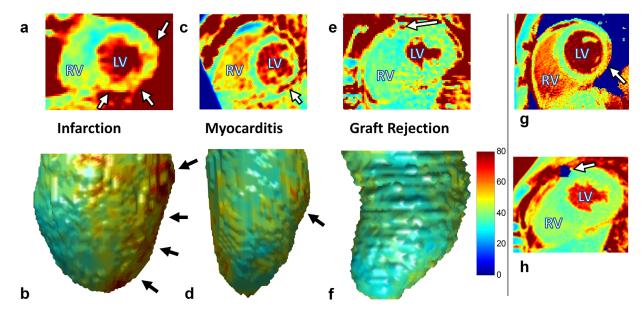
Short-axis slices and 3D volume renderings of the 3D  $T_2$  maps in three patients with established cardiovascular disease. a, b: A patient with a subacute myocardial infarction as confirmed through X-ray angiography. A region with significantly elevated  $T_2$  can be clearly identified (arrows). c, d: A patient with myocarditis that was established through prior clinical MRI. Several small regions of  $T_2$  elevation can be discerned (arrows). e, f: A patient with a cardiac graft and no rejection as seen in endomyocardial biopsy also demonstrates the absence of subendocardial elevated  $T_2$  values, although a small patch with elevated  $T_2$  can be observed at the anterior epicardium (arrow). This was later confirmed to be a stent. g: A region of elevated  $T_2$  can be observed in a control 2D  $T_2$  map at the same level as (c). However, the region is mostly epicardial and not transmural, which causes it to appear smaller in the 3D subendocardial segmentation. h: A control 2D  $T_2$  map at the same level as (e). The myocardium also does not show any  $T_2$  elevation, while the blue patch here is a nonmapped signal void, which was confirmed to be the same stent as in (e).
